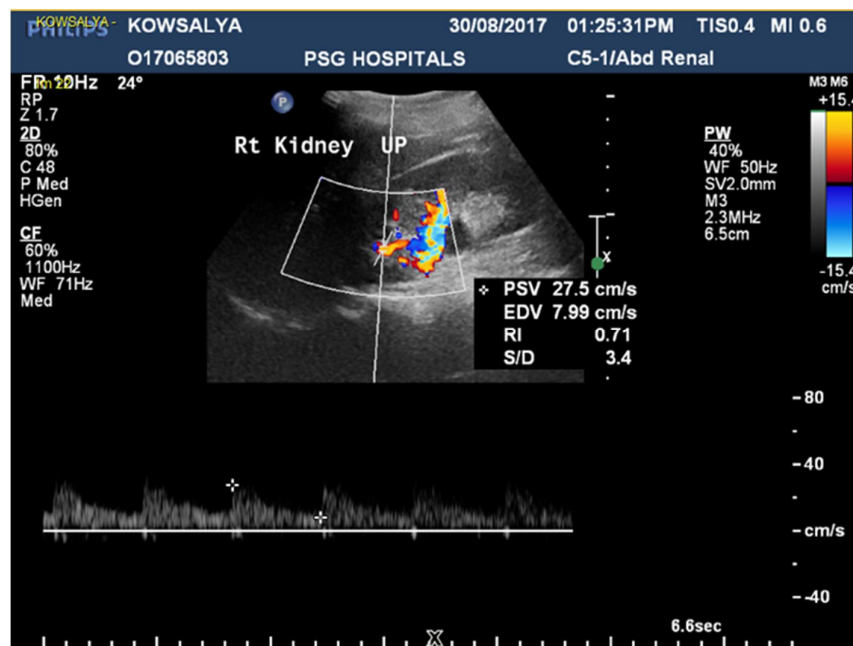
(C) Doppler US demonstrating an RI value of 0.71 in the upper pole of right kidney (obstructed).
